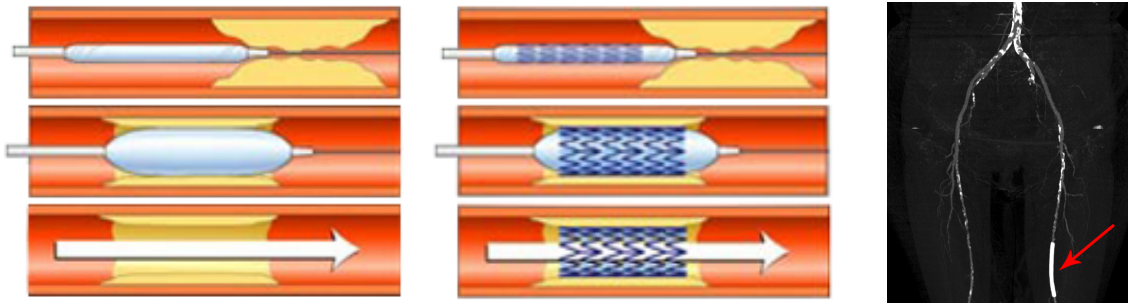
Treatment of atherosclerosis. The left image shows a balloon angioplasty to widen the narrowed vessel, whereas the middle picture presents the technique of stent implantation. In the right image a stent (red arrow) is acquired by a CT scanner and visualized using MIDA. (Source of the left and middle image: <http://www.herz-praxis.ch/>, right image created using the AngioVis Toolbox)*
